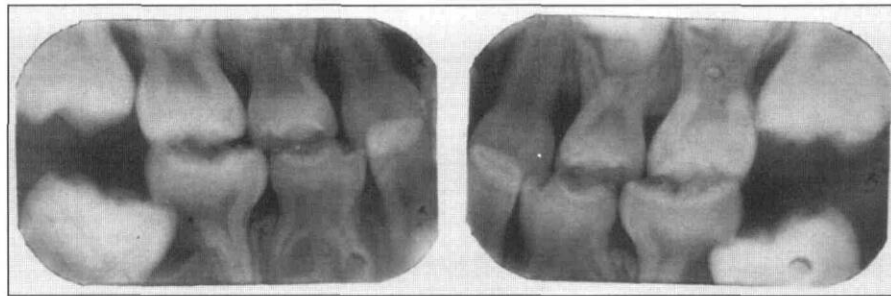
Bite-wing radiographs at age 7 years. Note the distal root resorption of both mandibular second primary molars.
